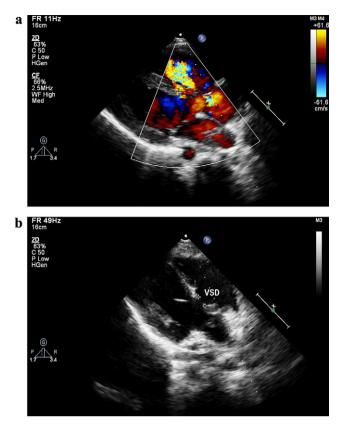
(a) and (b) A perimembranous ventricular septal defect (VSD) with left to right shunt and moderate tricuspid regurgitation on color flow Doppler imaging by transthoracic echocardiography.
